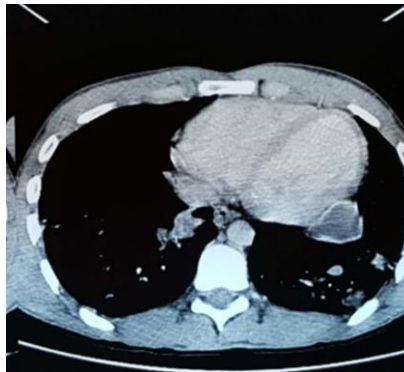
Thoracic CT scan. Cystic formation at the level of the cardiophrenic recess of 2 cm
